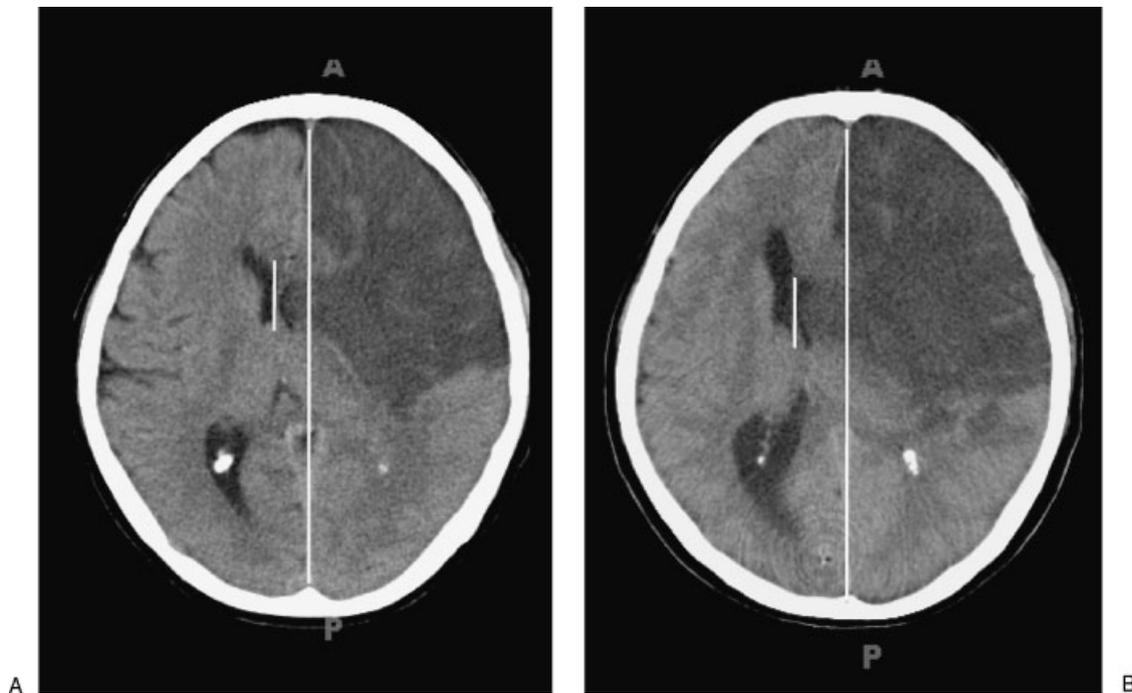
Computed tomography (CT) scans of a patient with a large carotid/ middle cerebral artery (MCA) distribution stroke. (A) Shows midline shift and a large area of cytotoxic edema. (B) Shows the same patient 2 days later despite maximal intracranial perfusion management. The patient had worsening mental status over the 2 days despite no new stroke events.
